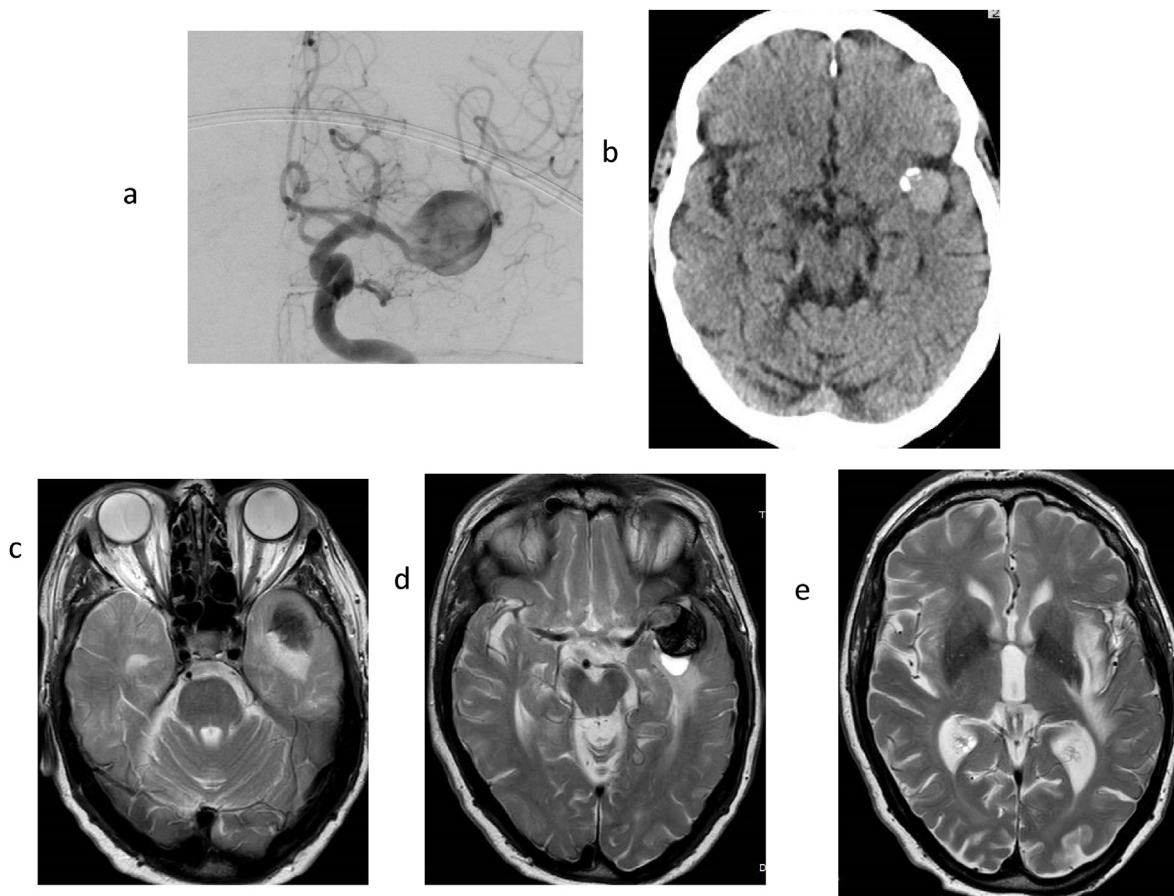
Frontal projection left internal carotid angiogram demonstrating the giant bifurcation left middle cerebral artery aneurysm (a), axial unenhanced cranial CT scan pre-embolisation demonstrating the aneurysm without associated oedema or cyst formation (b), and T2W axial MR images 6 months post-embolisation (c,d,e), demonstrating the development of oedema in the left temporal lobe, deep to the insula and in the posterior limb of the left internal capsule and optic radiations. Axial T2W MR images at 14 months post-embolisation (f,g,h), show some increase in oedema and enlargement of the cyst, 21 (i,j) and 27 (k) months post-embolisation and 33 (l,m) months post-embolisation, demonstrate further significant cyst enlargement with increasing oedema (i,j,k) and decrease in both oedema and cyst volume post shunt insertion (l,m). There has also been progressive ventricular enlargement, the result of a communicating hydrocephalus.
